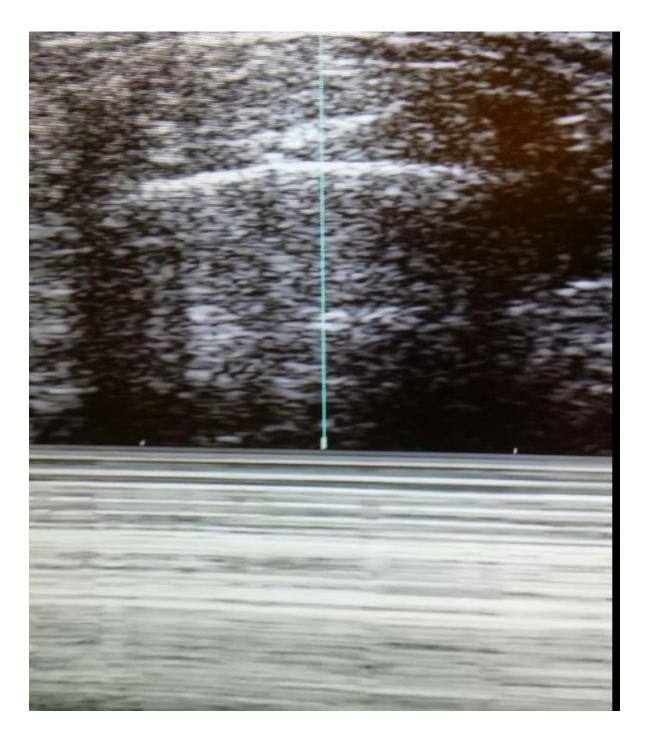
Pneumothorax as seen on ultrasound. M-mode clearly shows the barcode sign, indicating absent sliding.
